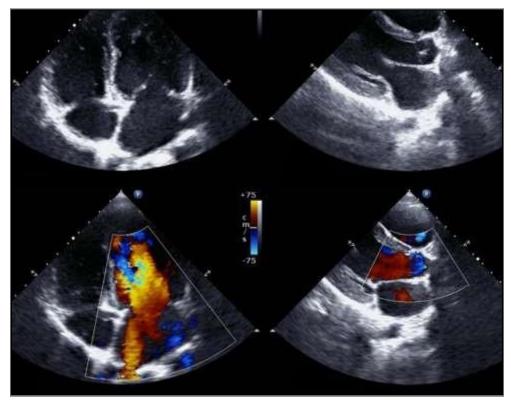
Echocardiography show pulmonary hypertension in infants. Laboratory investigations:
